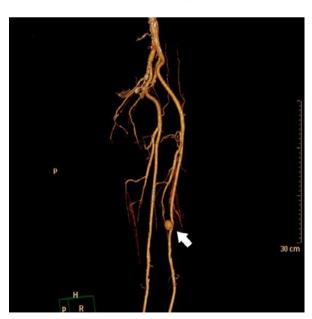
CT angiography: An eccentric saccular aneurysm arising from the middle third of the right superficial femoral artery.
